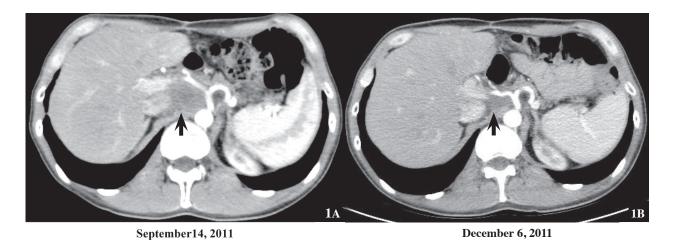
CT Upper abdomen at level celiac region, before treatment (1A) and after 2 courses of treatment (1B).
